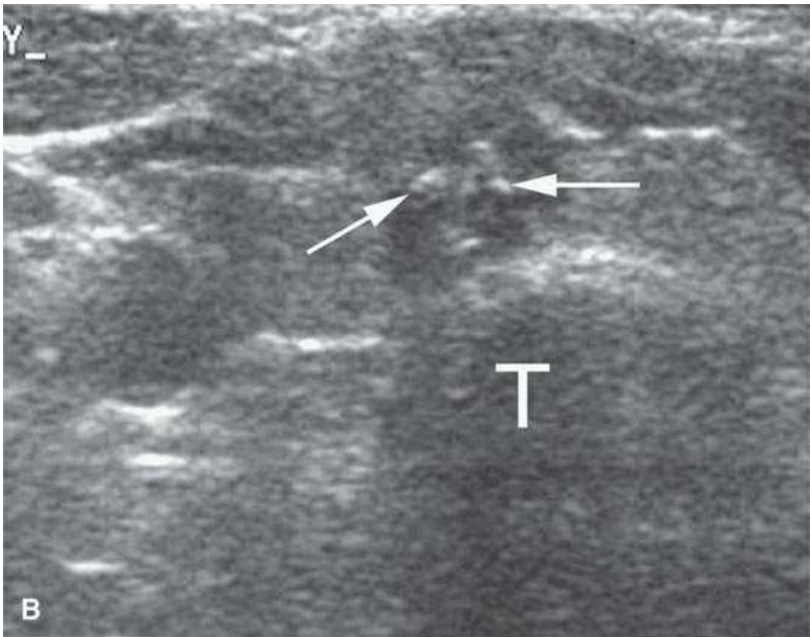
A: Non-contrast-enhanced computed tomography showing psammomatoid calcifications in the papillary thyroid cancer (*arrows*) and calcified level 6 nodes (*arrowheads*). High-level echoes in the mass (*arrows* in B and C) and acoustic shadowing (*arrowheads* in C) related to the calcification.
